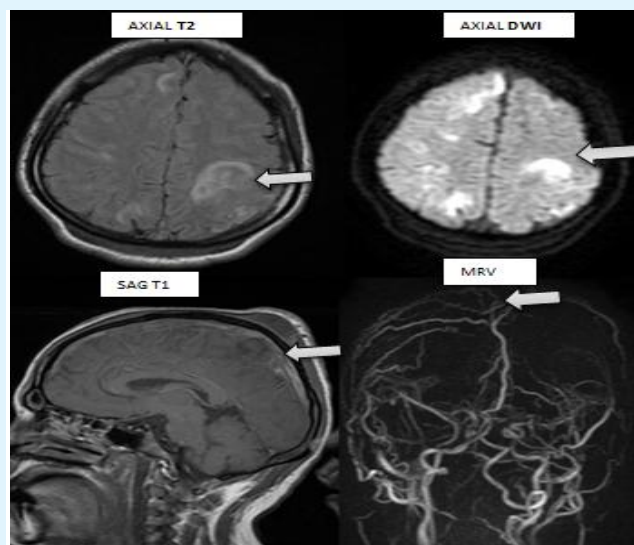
23 y old women with 5 months of amenorrhea day, c/o headache, Axial T2 FLAIR, DWI, Sag T1 and MRV reveals venous infarct in bilateral frontal lobe secondary to thrombosis of superior sagittal and bilateral transverse sinuses.
